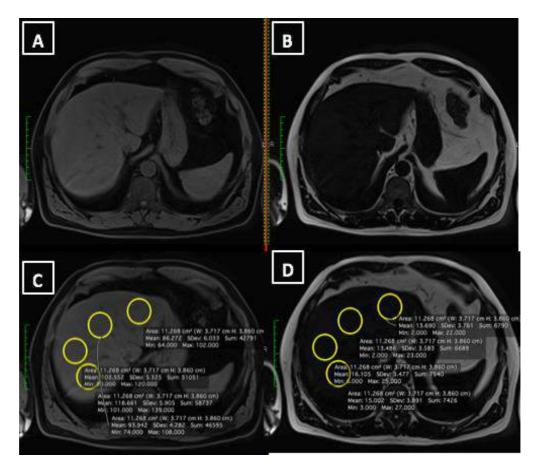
MRI images showing the information provided in the HOROS software for each region of interest from which the pixel signal intensities are used to determine percentage fat fraction of each ROI. Panels A and B represent images C and D respectively.
